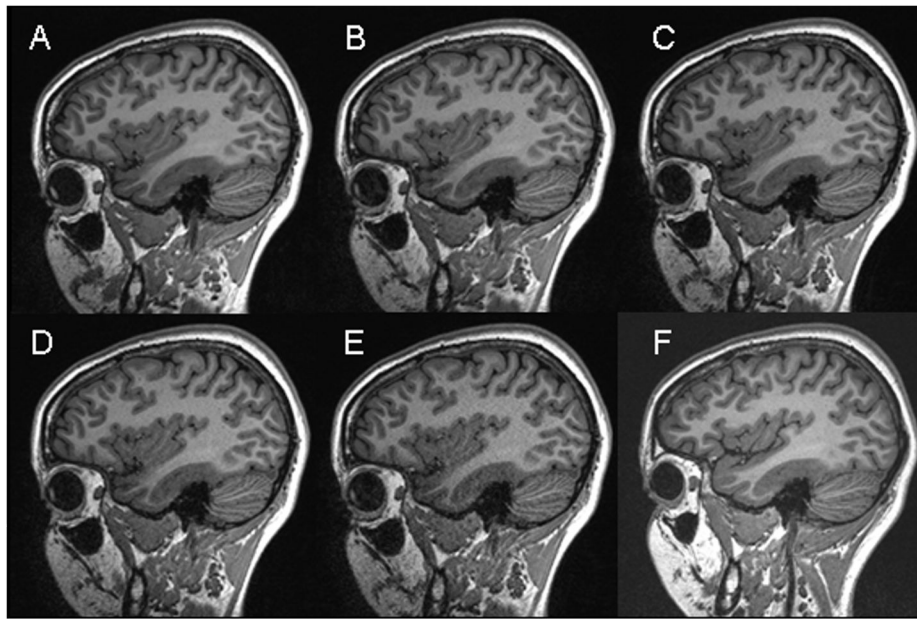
High-resolution T1-weighted MPRAGE images (TR/TI/TE/flip = 2300/900/6ms/9°, 1.0×1.0×1.2 mm³, matrix = 240×256) from one subject acquired with the 32-channel head coil without acceleration (A), and with 2-, 3-, 4- and 5-fold acceleration (B–E). A corresponding image acquired at the end of the rescan session using the standard 12-channel head matrix product coil without acceleration is shown in (F).
